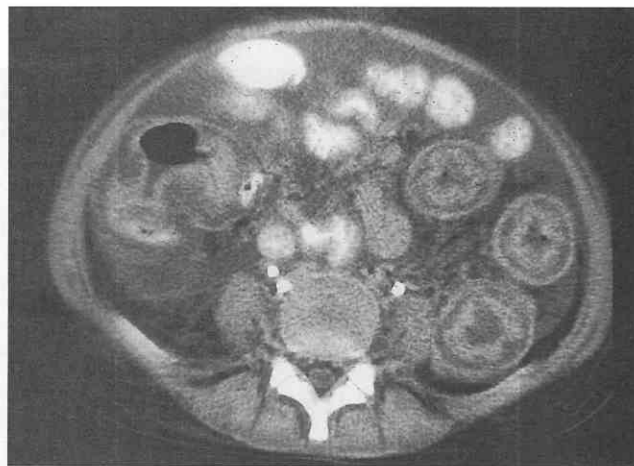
Pseudomembranous colitis. CT scan through the lower abdomen in a patient with pseudomembranous colitis demonstrates diffuse colonic wall thickening. The wall has a homogeneous, low-attenuation appearance.
